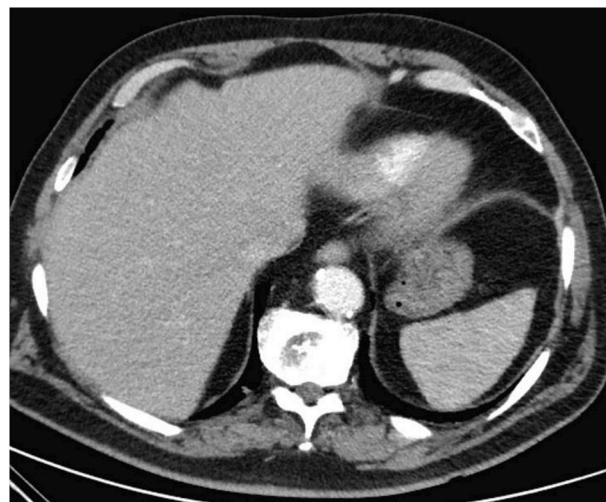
Initial CT thorax with contrast, axial view, showing no concerning liver lesions.
